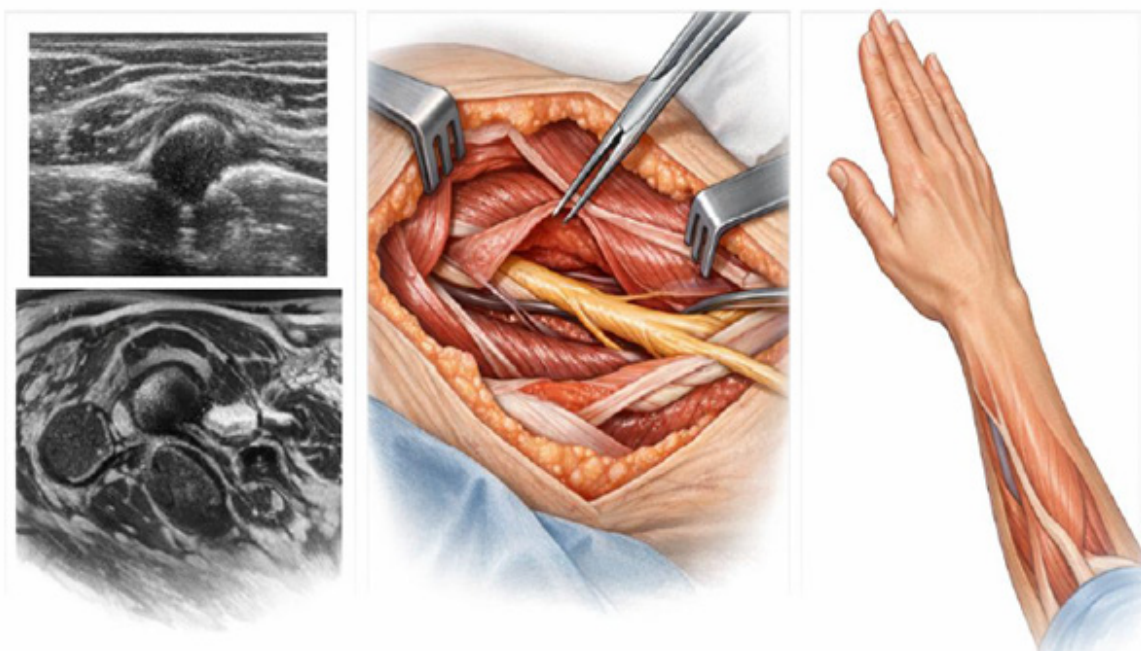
Three-phase clinical management of Posterior Interosseous Nerve Syndrome: multimodal diagnosis (ultrasound and MRI), surgical decompression at the Arcade of Frohse, and functional recovery with restoration of motor control.
